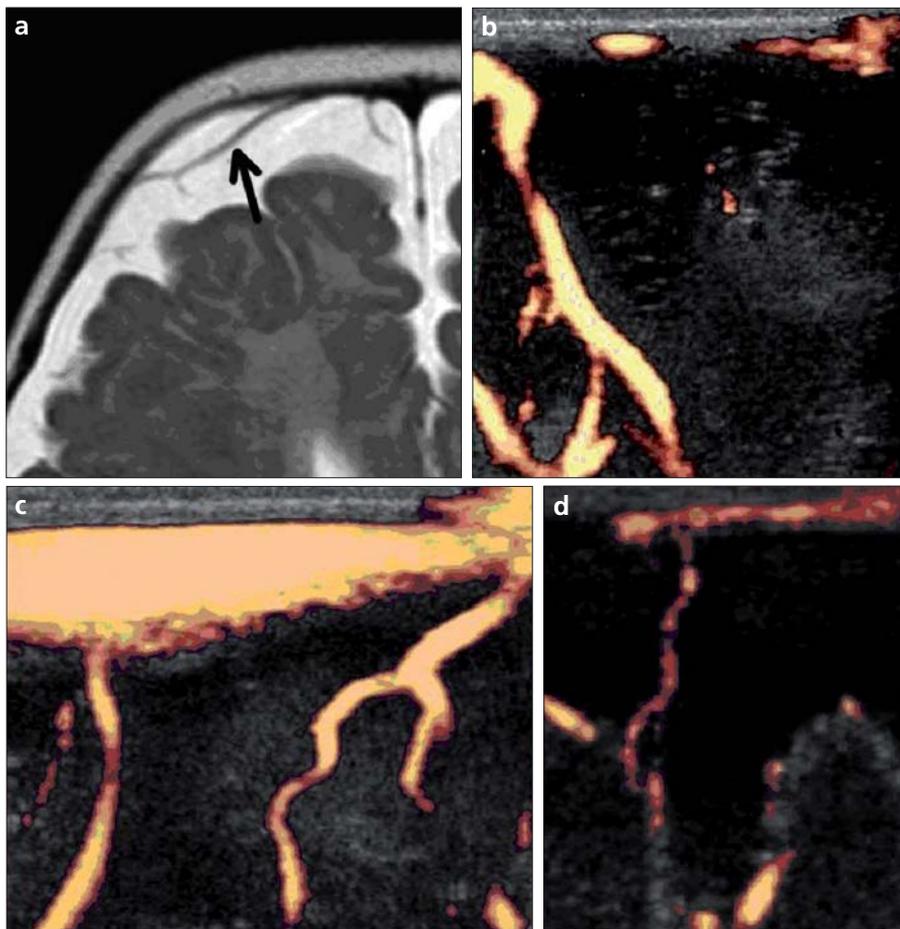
a–d. Positive cortical vein sign on axial T2-weighted MR image (a) and cortical veins visualized with power Doppler US (b–d) in the subarachnoid space in a case of benign subarachnoid space enlargement.
